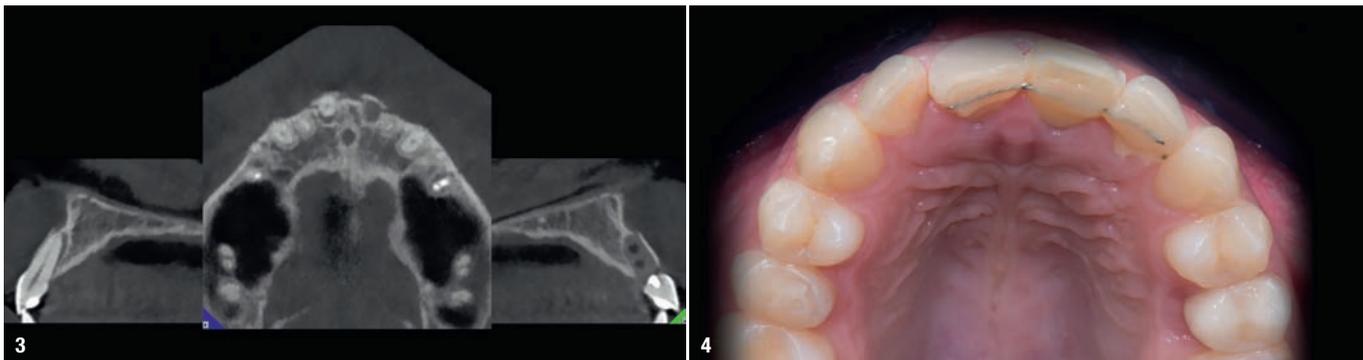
CBCT scan after the trauma. Fig. 4: Emergence solution.
